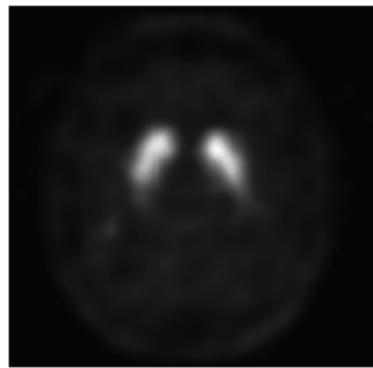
Normal DAT SPECT Image
